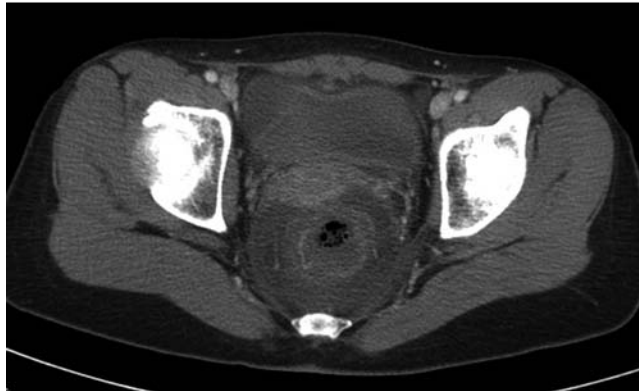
Computed tomography (CT) images of the abdomen and pelvis show marked edematous wall thickening in the entire rectum and surrounding fluid collection consistent with rectal burns.
